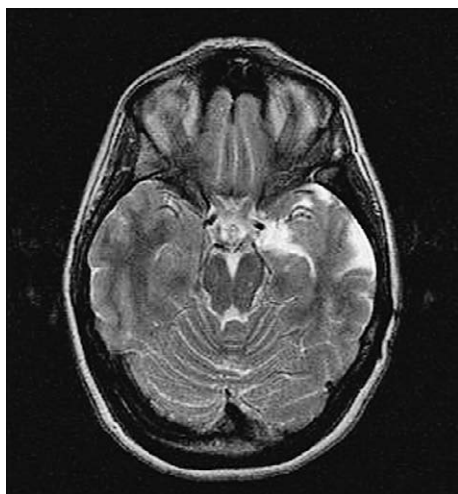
Postoperative magnetic resonance imaging of the brain (T2 axial weighted image): resection area involving the left uncus and amygdala.
